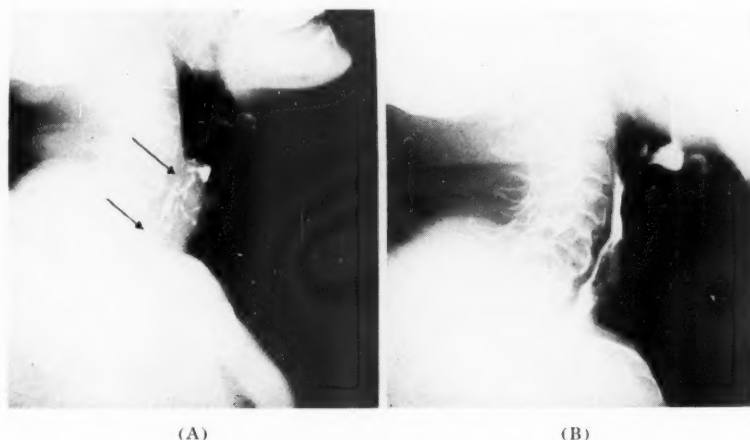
Case 2: Roentgenograms showing (A) the large tumor of the cervical esophagus causing marked tracheal compression and (B) postradiation regression. The patient is alive and well over four years.
